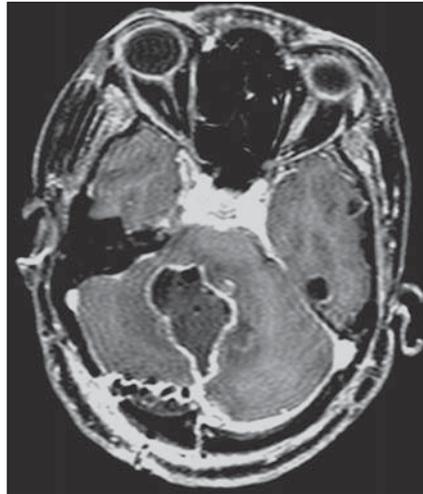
Axial, contrast-enhanced MRI, T1-weighted sequence demonstrating intense contrast-enhancement on the margins of the surgical site, and a hypodense, unenhanced lesion obliterating the IV ventricle. There are foci of marked hyposignal within the lesion and in the surgical pathway, particularly in the right posterior region, already identified on the non-contrast-enhanced study, possibly corresponding to the presence of air/gas.
